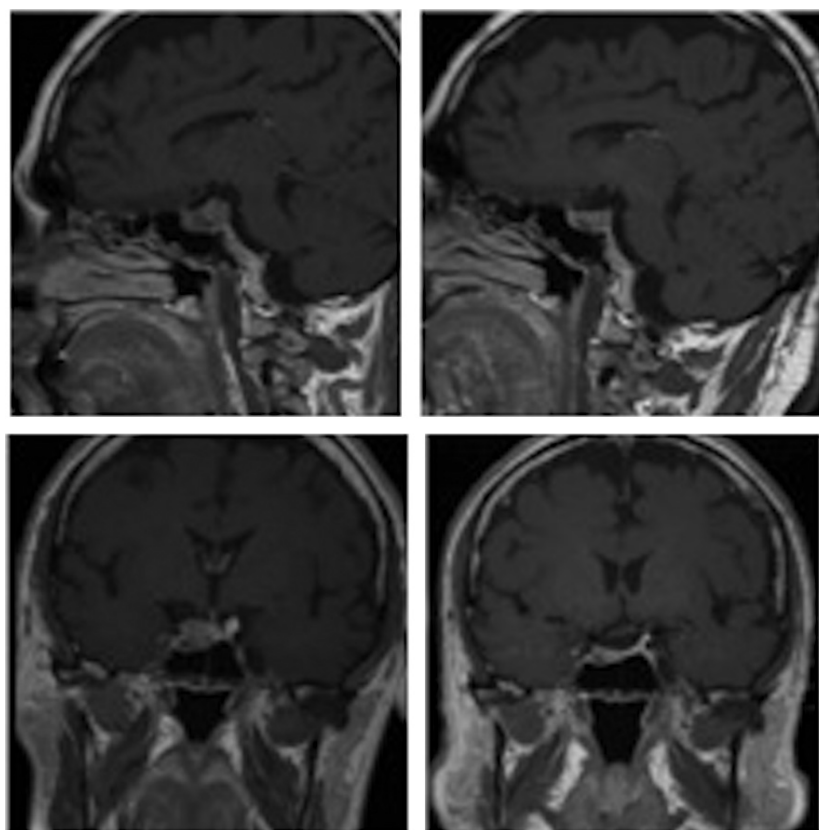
Gadolinium enhanced MRI studies performed at baseline (left) and after 12 months (right) of treatment with pasireotide 300 μg subcutaneously (s.c.) two times a day (b.i.d.).
